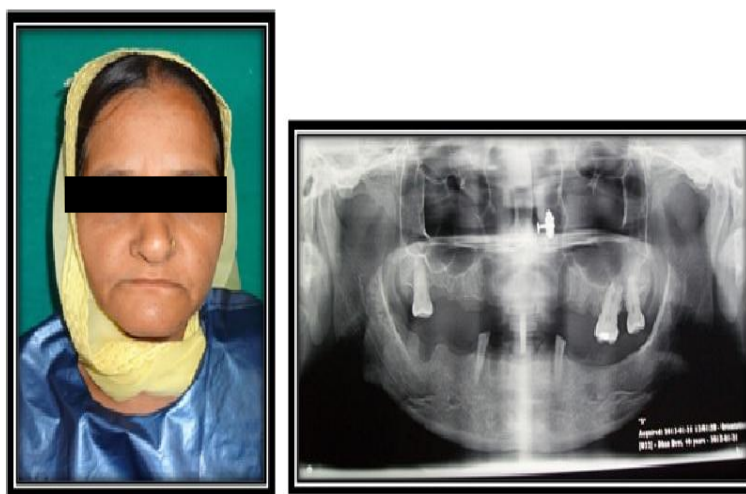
Pre-rehabilitative extra-oral view and Radiograph
